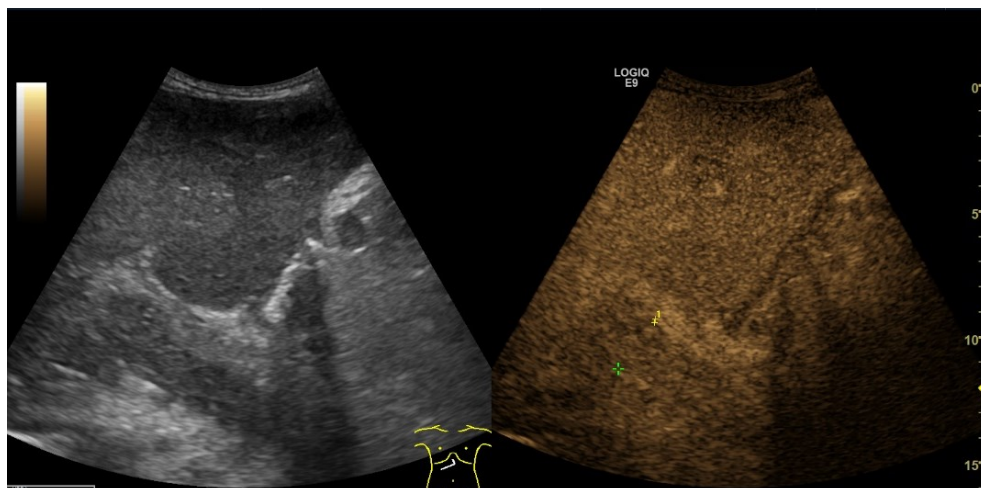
Contrast-Enhanced Ultrasound (CEUS) for Portal Vein Thrombosis. CEUS examination demonstrates contrast enhancement within the portal vein thrombus, a characteristic feature of malignant portal vein thrombosis (tumor invasion of the vein). These findings support the diagnosis of tumor thrombus rather than bland thrombosis.
